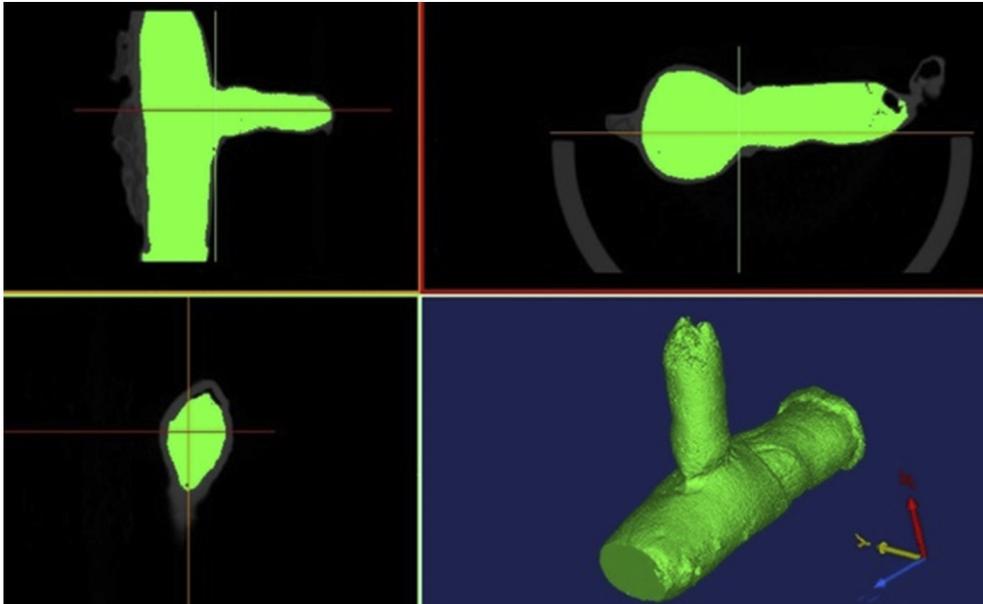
Micro-computed tomography-scan of the 90° ETS Anastomosis.
